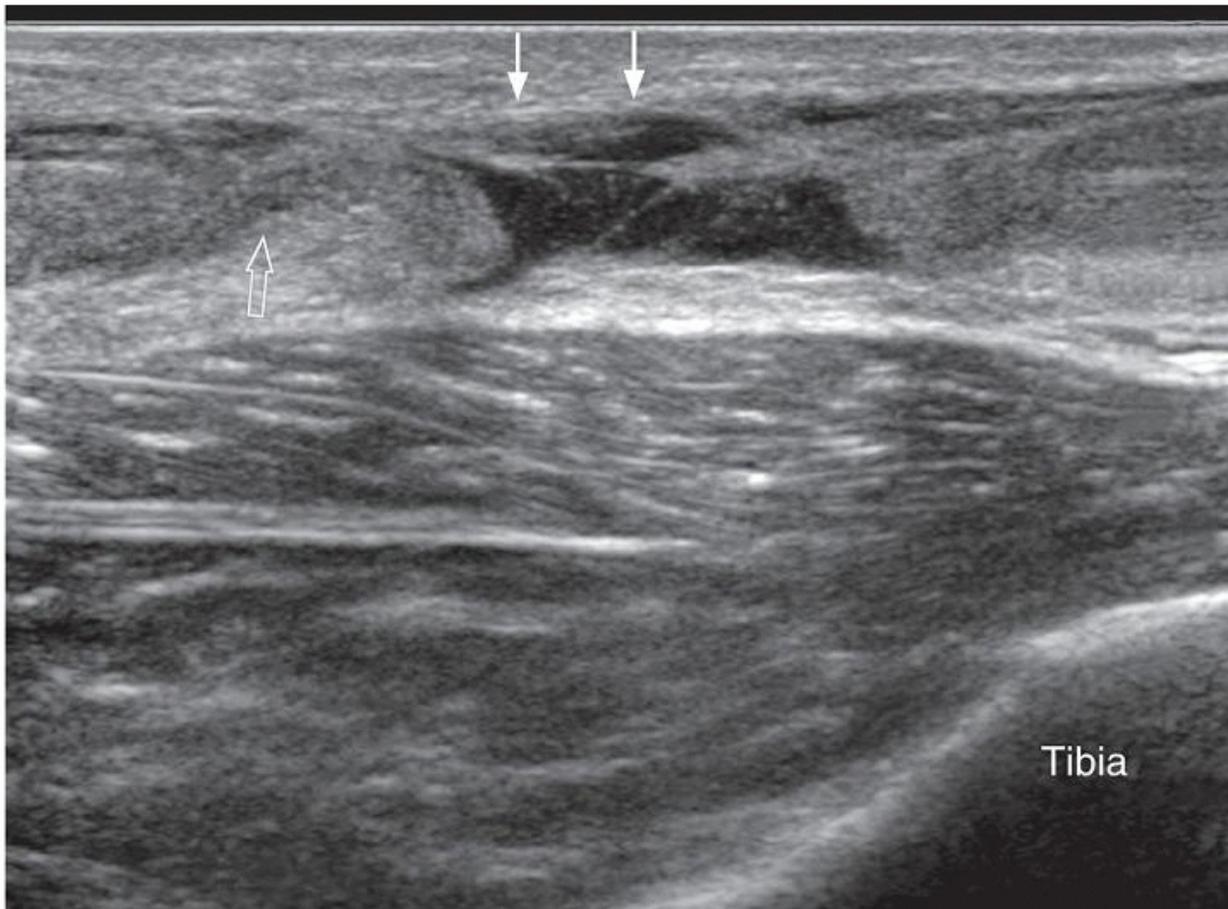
Longitudinal ultrasound showing complete Achilles tendon tear (arrows) just distal to the musculotendinous junction (open arrow). The tendon gap is filled with fluid.
